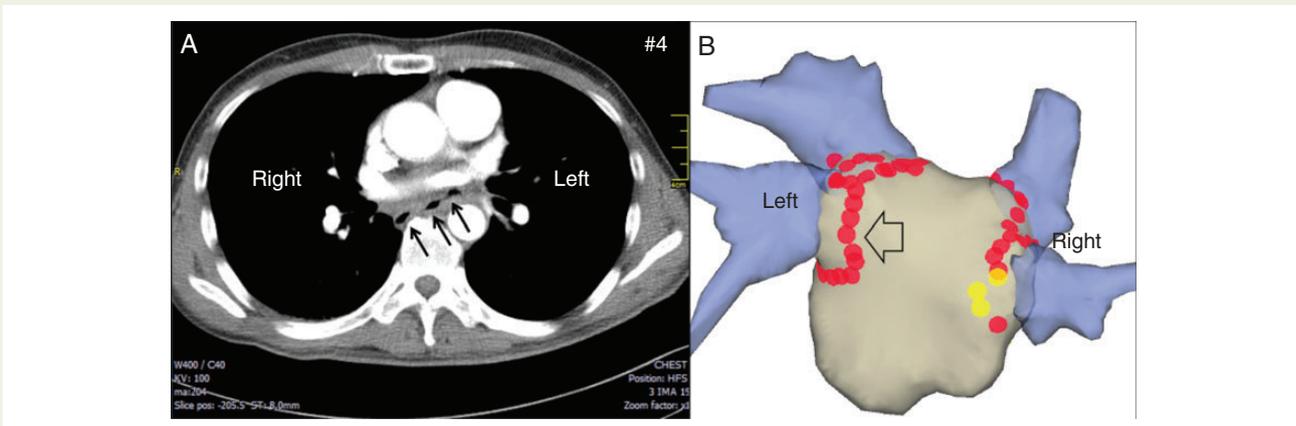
Images from patient 4 of the series. (A) Chest CT image demonstrating the presence of AEF outlined by air propagating from oesophagus towards left inferior pulmonary vein antrum (arrows). Note that fistula trajectory from the left atrium is orthogonal to the oesophagus position. (B) Electroanatomic mapping image (posterior view) obtained during ablation. Spherical markers identify isolation lines around pulmonary veins antra. In this case, the region in which oesophageal temperature increased (yellow markers) does not correspond to the left atrium region where AEF formed (open arrow).
